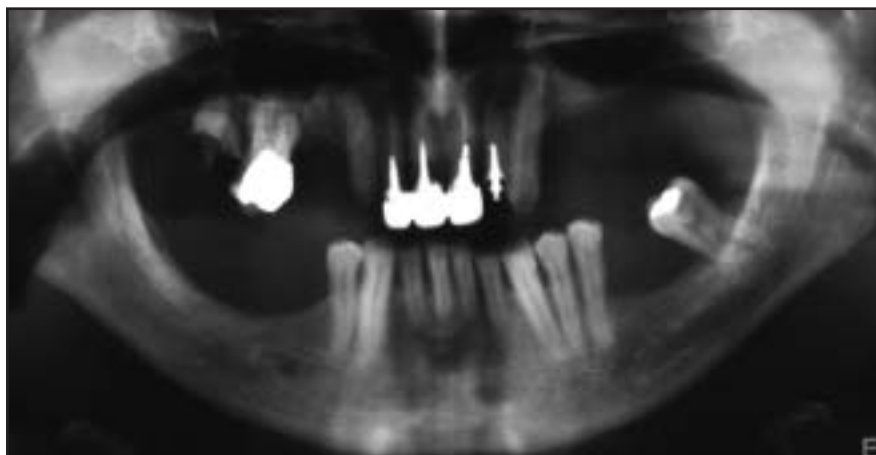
(left) Pretreatment panoramic radiograph. Note the extensive alveolar bone loss.
